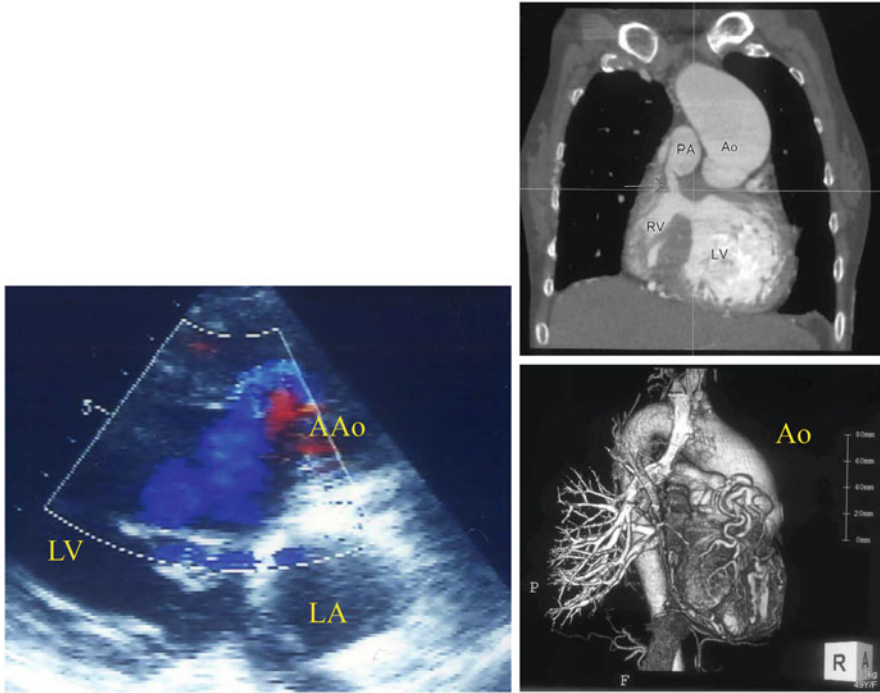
A 50-year-old female, tricuspid atresia (1b), post-Glenn procedure, right aortic arch, moderate aortic regurgitation, ascending aortic diameter: 50 mm. *Left panel:* Severe aortic regurgitation by echo. *Right panel:* Dilated ascending aorta by MRI. AAO ascending aorta, LV left ventricle, LA left atrium (Courtesy by Dr. Katayama H.)
